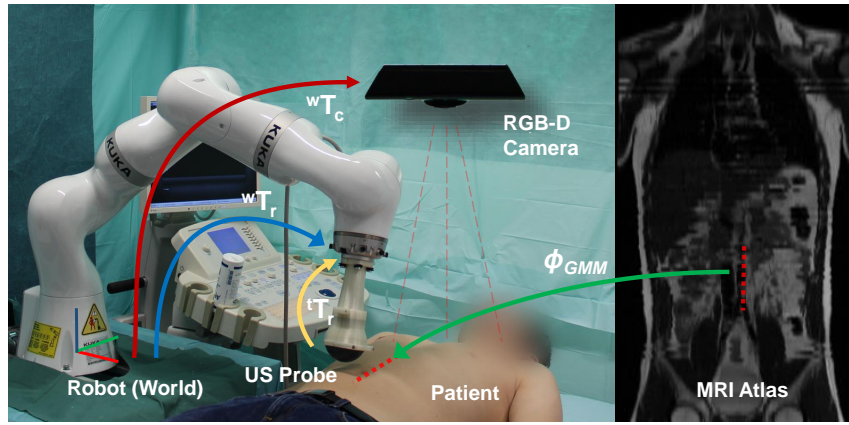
System setup showing the robot, the US transducer mounted to its end-effector, the RGB-D camera on the ceiling, the patient, a coronal slice of the MRI atlas, and all required transformations. *Reprint from [230], ©2016 IEEE.*
